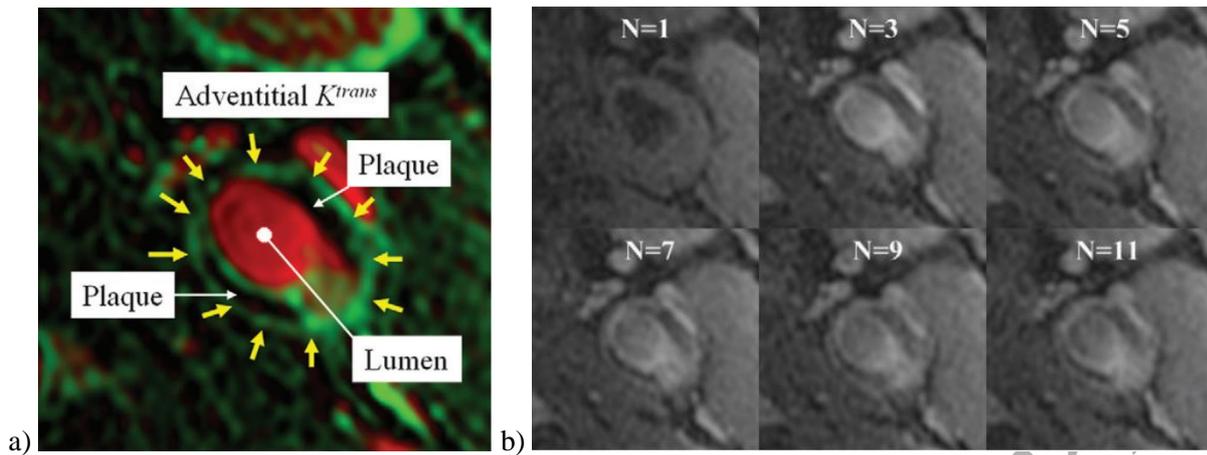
MRI of carotid vasa vasorum. a) Display of the kinetic modelling: Regions with flowing blood, such as the carotid artery lumen appear in red;  $v_p$ , regions with rapid transfer, such as the vessel adventitia (arrows) appear in green:  $K^{trans}$ . b) Representative sequence of DCE-MRI frames obtained before (image frame  $N = 1$ ) and other frames after bolus injection of the contrast agent.
